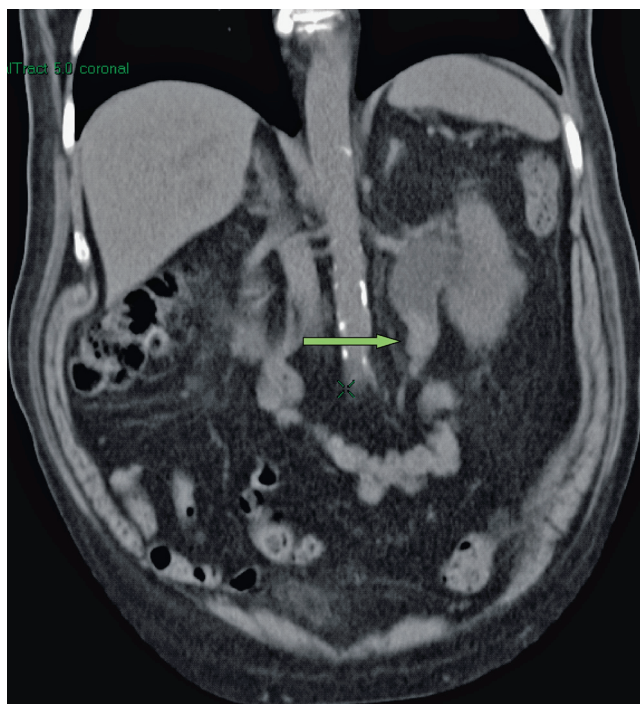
Ureteric tumor (green arrow) causing obstruction of the left kidney on CT KUB
